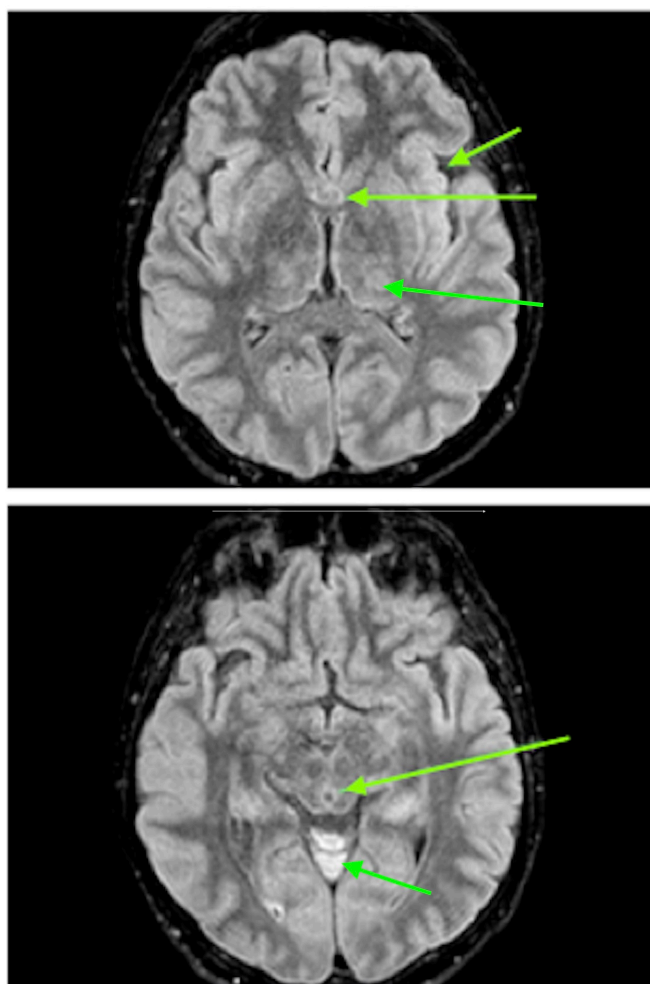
MRI: Signs of encephalitic involvement with hyperintensity of the cerebellar cortex, thalamus, hypothalamus, insular cortex, anterior temporal cortex, periaqueductal gray matter and polar cortex with bilateral distribution (green arrows).
